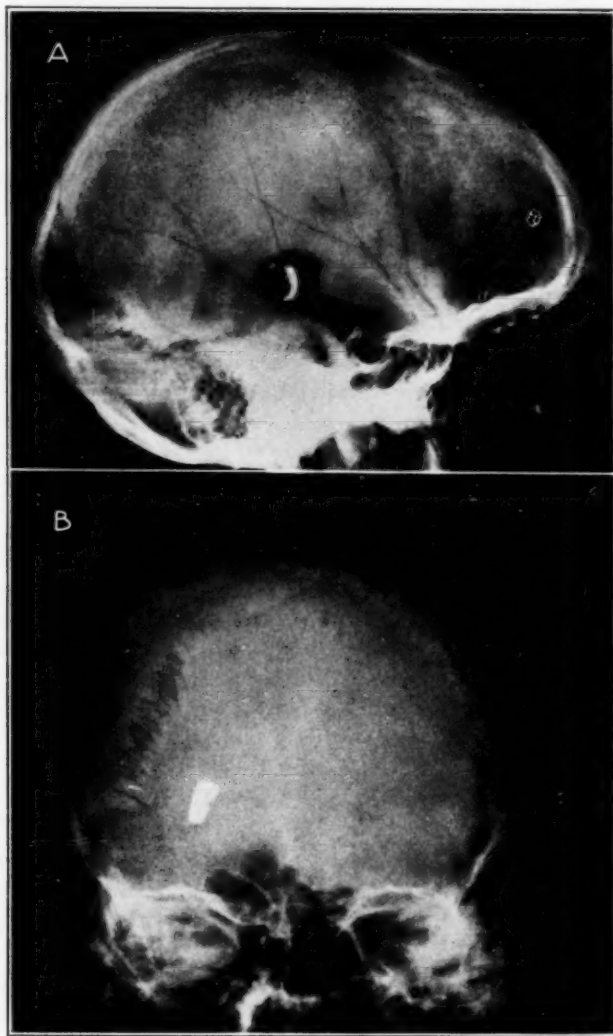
(case 1).—Roentgenograms of the skull, right lateral (*A*) and antero-posterior (*B*) views. On Aug. 2, 1945 (ten months after the injury) the largest metallic fragment was surgically removed from the lower anterior portion of the thalamus. The state of the fields and the dynamic aspects of the patient's visual organization were unchanged after this operation.
